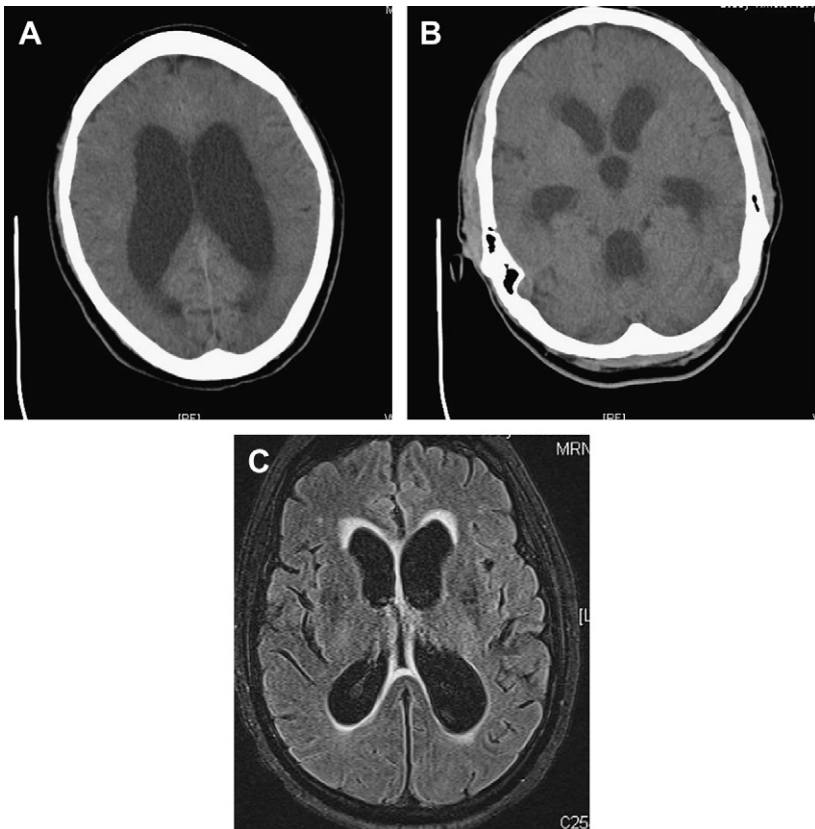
Acute hydrocephalus complicating meningitis. CT scan of patient with *Coccidioides immitis* meningitis. Like many such patients with fungal meningitis, this patient required ventriculoperitoneal shunting. The lateral ventricles on the unenhanced CT (A) are huge and there is transependymal spread of fluid across the ependymal surface. Lateral third and fourth ventricles are symmetrically enlarged (B), demonstrating that circulation of CSF is impeded at the level of the arachnoid villi. (C) FLAIR MRI of patient with community-acquired *S pneumoniae* meningitis also with acute hydrocephalus, a poor prognostic sign.
